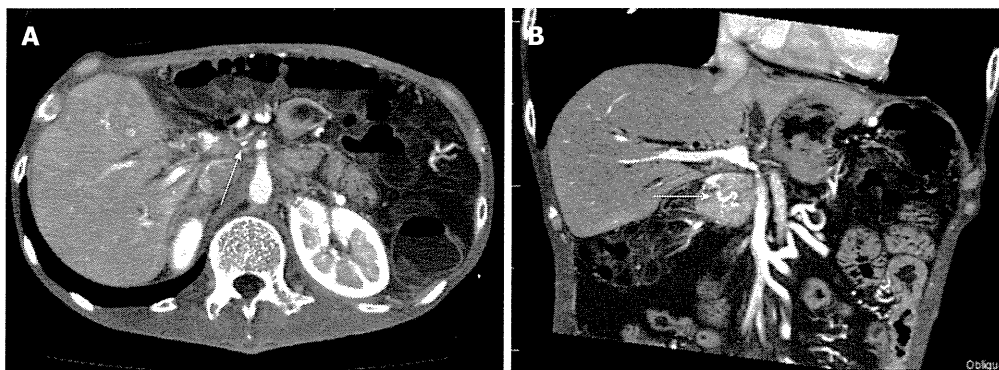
Computed tomography showed short segmental stenosis of the portal vein in the region of the anastomosis, severe ascites, and liver atrophy. A, B: Computed tomography (CT) scan shows severe ascites and liver atrophy (arrow) (A), and stenosis of the portal vein (arrow) behind the superior mesenteric artery (B); C: The image of the 3D reconstruction of the portal vein shows short segmental stenosis in the region of the anastomosis (arrow).
